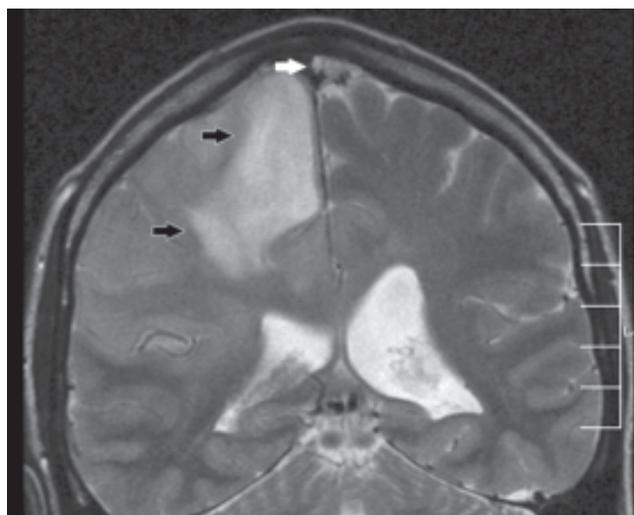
The pachymeningeal chloroma – T2-weighted coronal MR image shows small left parasagittal meningeal mass near superior sagittal venous sinus (white arrow) showing T2 hyperintensity. In addition, there is right hemispheric glioma (black arrows) with large perifocal edema and compression of right lateral ventricle.
